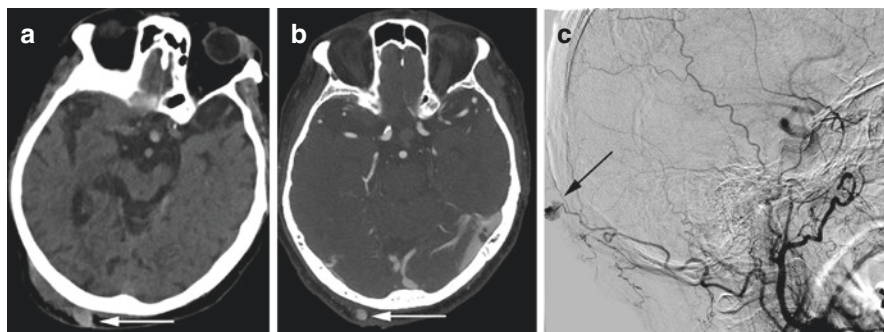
Occipital artery pseudoaneurysm. Patient with a right occipital scalp laceration after ground level fall. Noncontrast CT showed a rounded hematoma along the right occipital scalp (a, arrow). The hematoma began to pulsate, and CTA was performed which showed a pseudoaneurysm (b, arrow). DSA confirmed the pseudoaneurysm was supplied by the occipital artery (c, arrow). This was subsequently embolized
